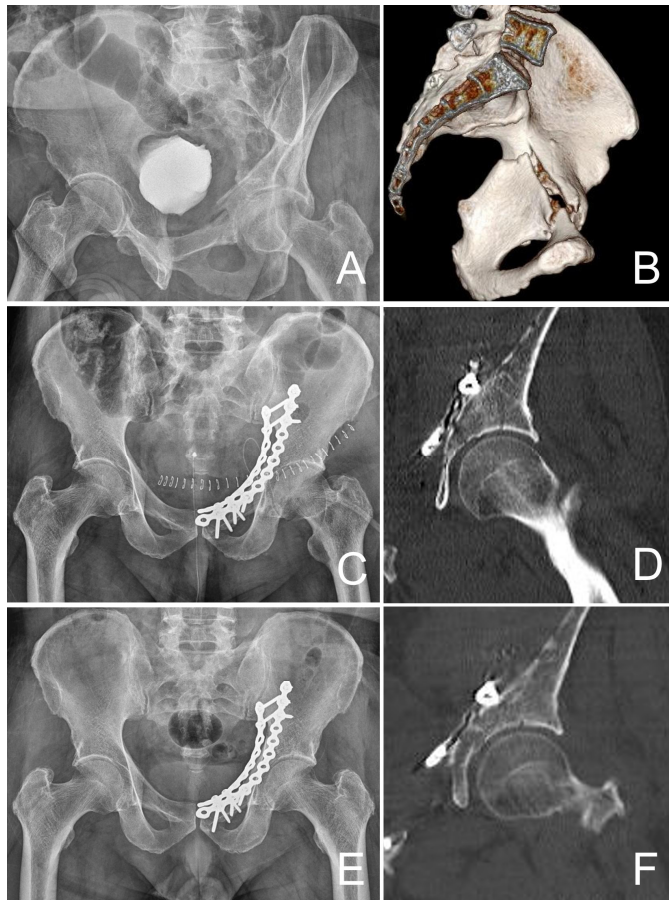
Case presentation II. A 66-year-old man underwent direct fixation with infrapectineal plate. (A) Radiograph shows both column fracture with 13 mm displacement. (B) Three-Dimensional CT scan shows both column fracture with quadrilateral plate displacement. (C) Direct reduction and fixation with infrapectineal plate is done. (D) CT scan shows anatomical reduction. (E) Radiograph obtained 24 months after surgery shows union at the fracture site and excellent grade with Matta's outcome grading. (F) CT scan also shows no sign of osteophyte, joint space narrowing, subchondral sclerosis and femoral head collapse. CT: computed tomography.
